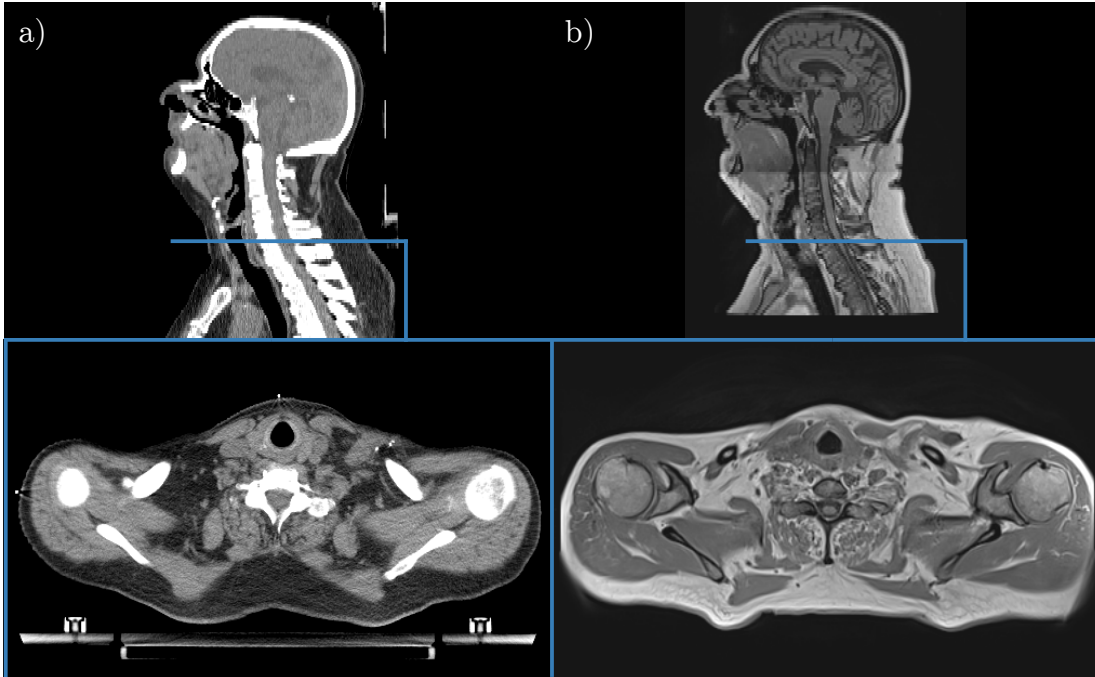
Image quality of CT and MRI slices for patient 1_{MRI}. a) Sagittal and transversal slice for the CT indicating the measured field-of-view. The blue line indicates the position of the transversal slice. b) Manually aligned and resampled corresponding slices of the MRI.
